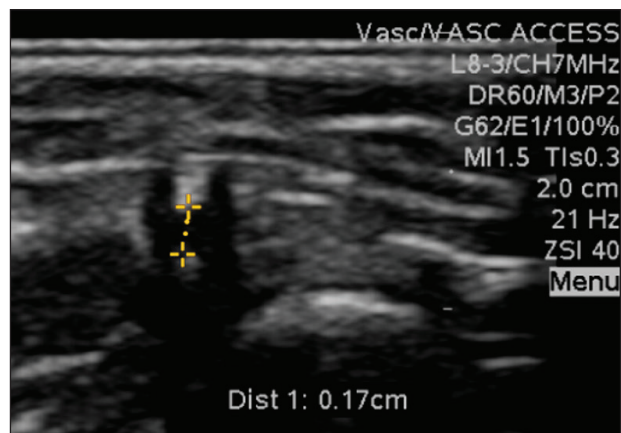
Grayscale ultrasound of the arm shows a left radial artery (dashed line) less than the 2-mm threshold.
